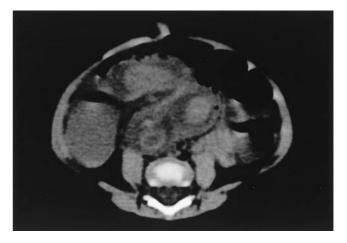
Preoperative computed tomography scan showed a manifest bowel-within-bowel appearance
